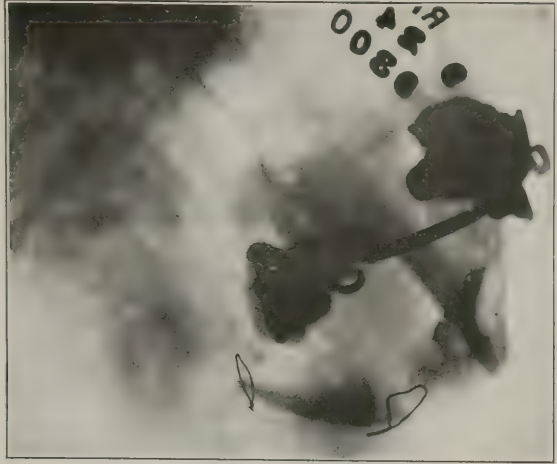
Case 8: Radiograph made one month after operation, showing graft in position.
